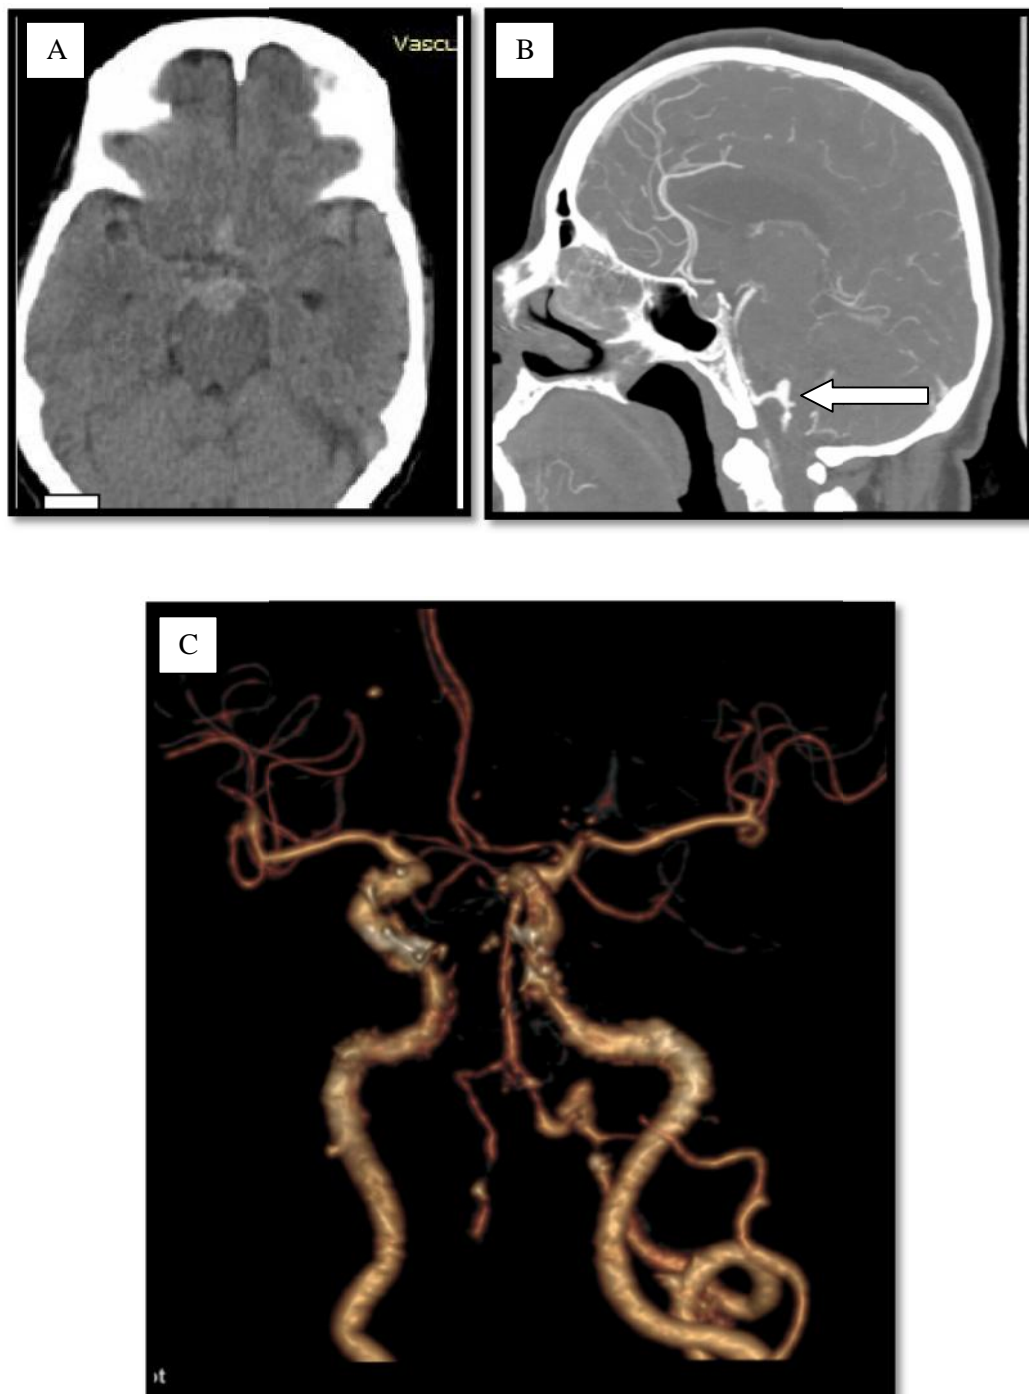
54-year-old male with aneurysm of V4 segment of Left vertebral artery (A) Axial precontract CT showing subarachnoid haemorrhage (B) sagittal MIP arterial phase (C) VRT showing saccular aneurysm of V4 segment of Left vertebral artery
